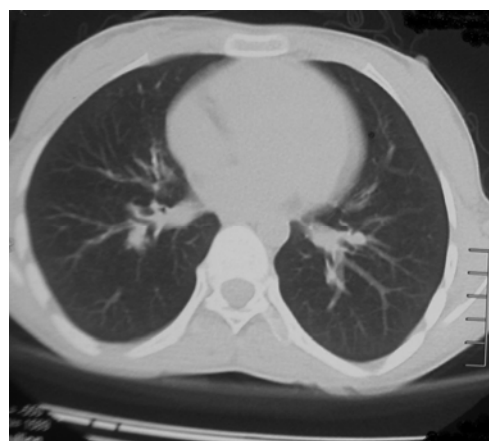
Chest CT of the patient after chemotherapy
